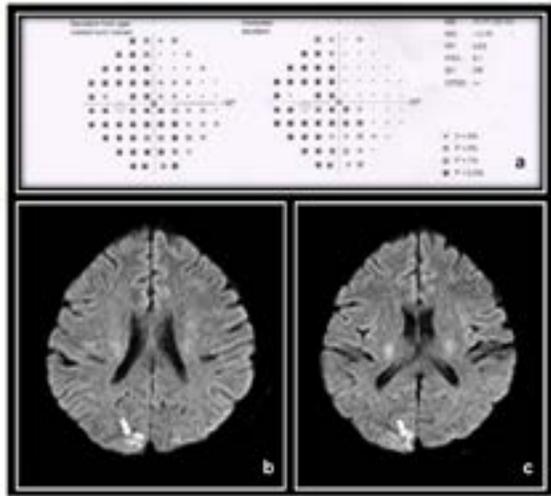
Oculus centerfield perimeter (30-2 program) of left eye (a) showing prominent temporal hemianopia defect involving macular area. Magnetic resonance imaging - Diffusion Weighted Images (b, c) showing small areas of true restricted diffusion (white arrow) in right occipital lobe suggestive of acute infarction.
